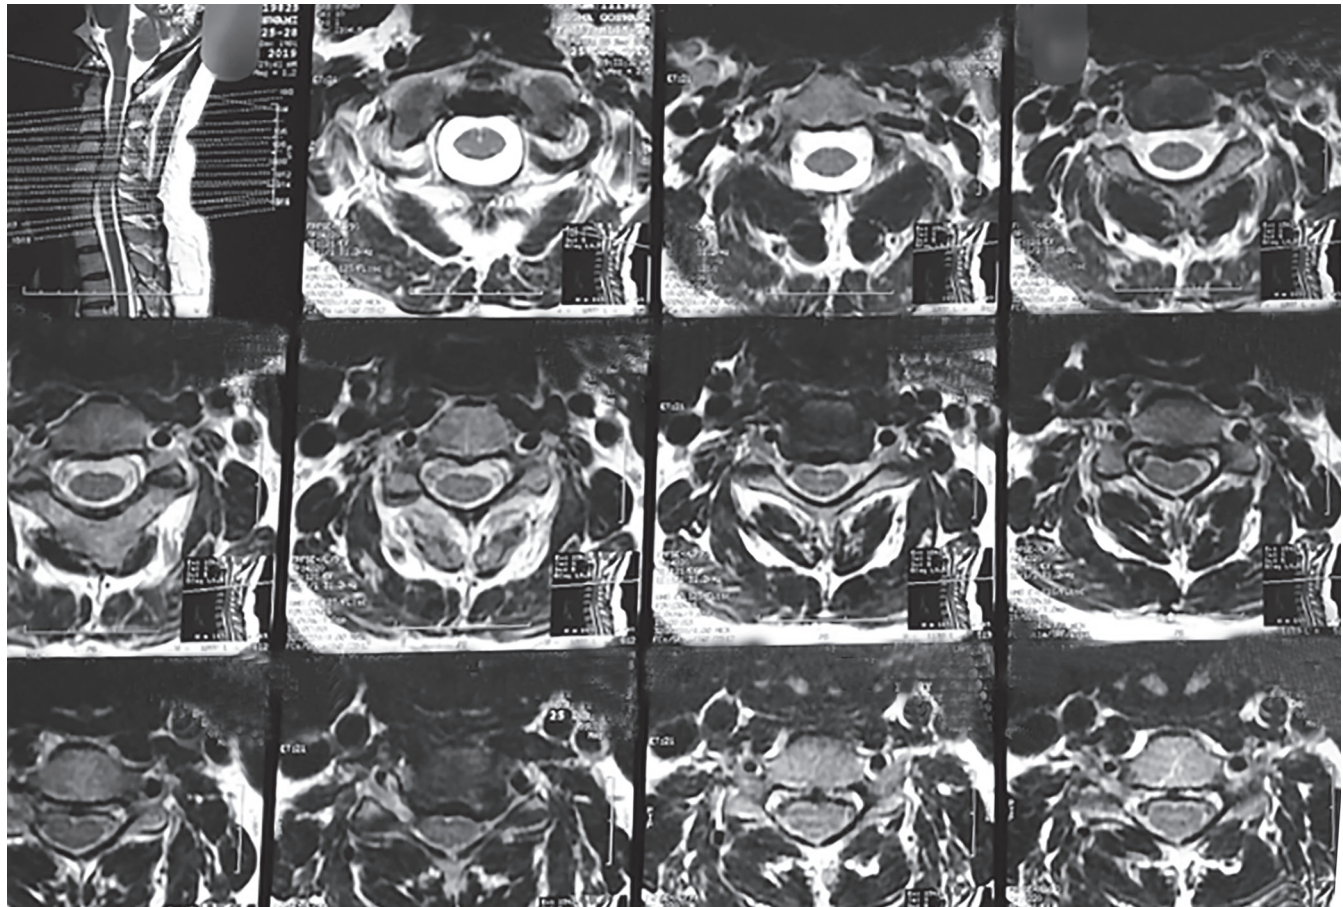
Magnetic resonance imaging of cervical spine (different sections)
